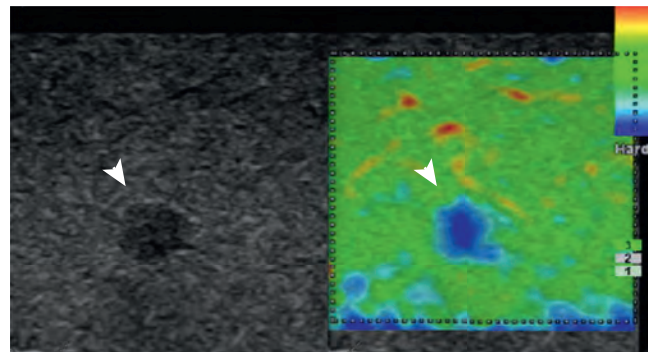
Real-time elastography. A 4-mm hypoechoic nodule (*arrow, left panel*) was found with Doppler ultrasonography with vascular flow internally. Real-time sonoelastography suggested a hard nodule (with this equipment blue is hard, not soft). Close follow-up with ultrasound examinations every 3 months found no increase in size of the nodule, and it was considered "probably" benign. (From Goddi A, Sacchi A, Magistretti G, Almolla J. Real-time tissue elastography for testicular lesion assessment. *Eur Radiol* 2012;22:721–30.)
